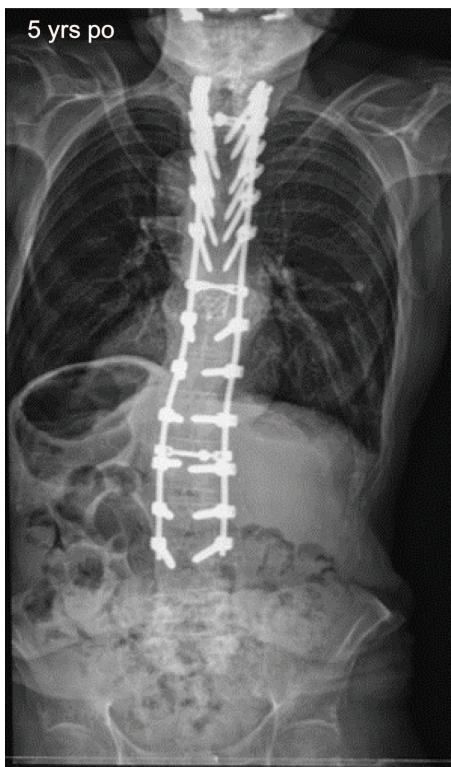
Five-year postoperative coronal radiograph after a 2-level posterior vertebral column resection and T2–L4 posterior spinal fusion.
